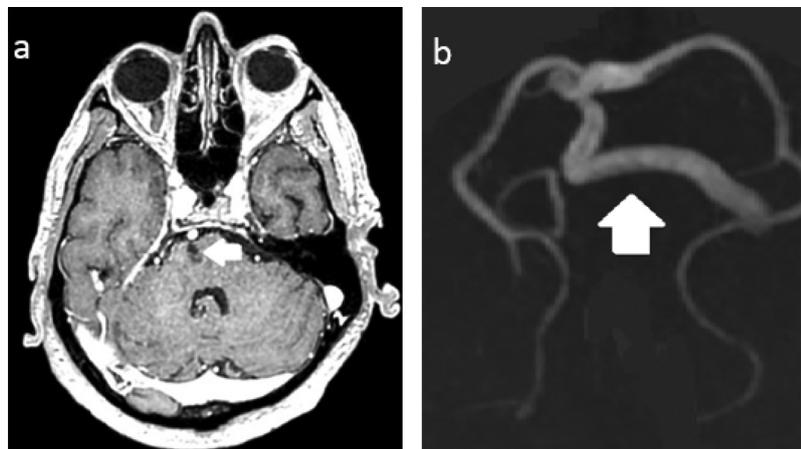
Follow up MRI at 6 months. (a): MRI in T1 gadolinium sequence shows sequelae in the central and right pons (Arrow); (b): MRI in time of flight sequence shows a normal circulating flow in the basilar artery (Arrow).
